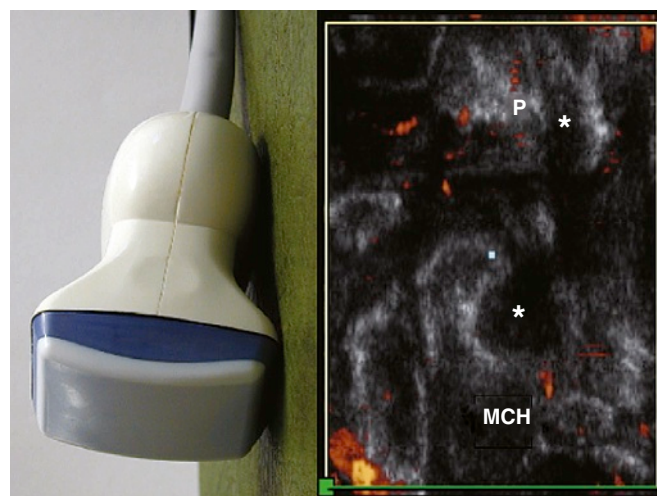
A three-dimensional volumetric probe was used to capture the coronal ultrasound image on the right. The footprint size is 38.4×44.5 mm. The probe is held still while an image is acquired within 5 seconds. The block of tissue can then be interrogated in various planes. In this image, large erosions (asterisk) are seen in the metacarpal head (MCH) and base of the phalanx (P) in a patient with long-standing rheumatoid arthritis.
